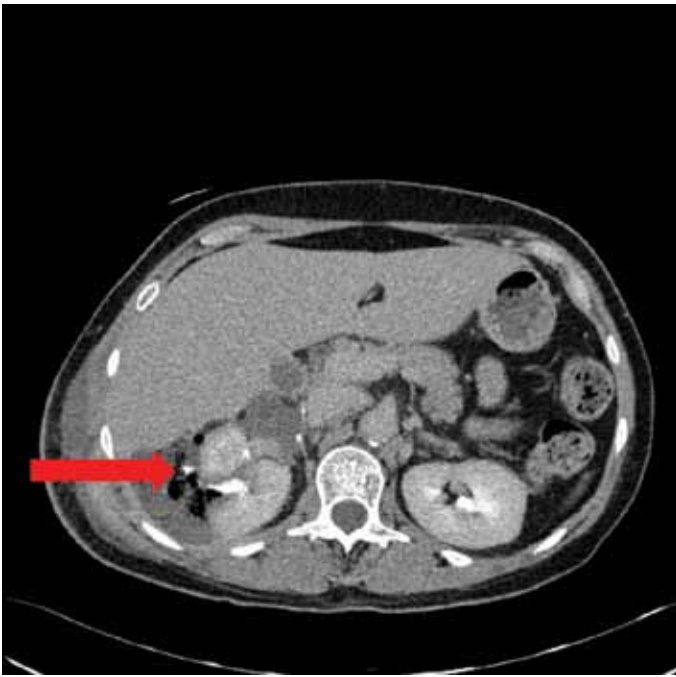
Delayed phase CT of abdomen with intravenous contrast shows extravasation of contrast material suggestive of urinary leak (arrow) from collecting system after right-sided PN.
